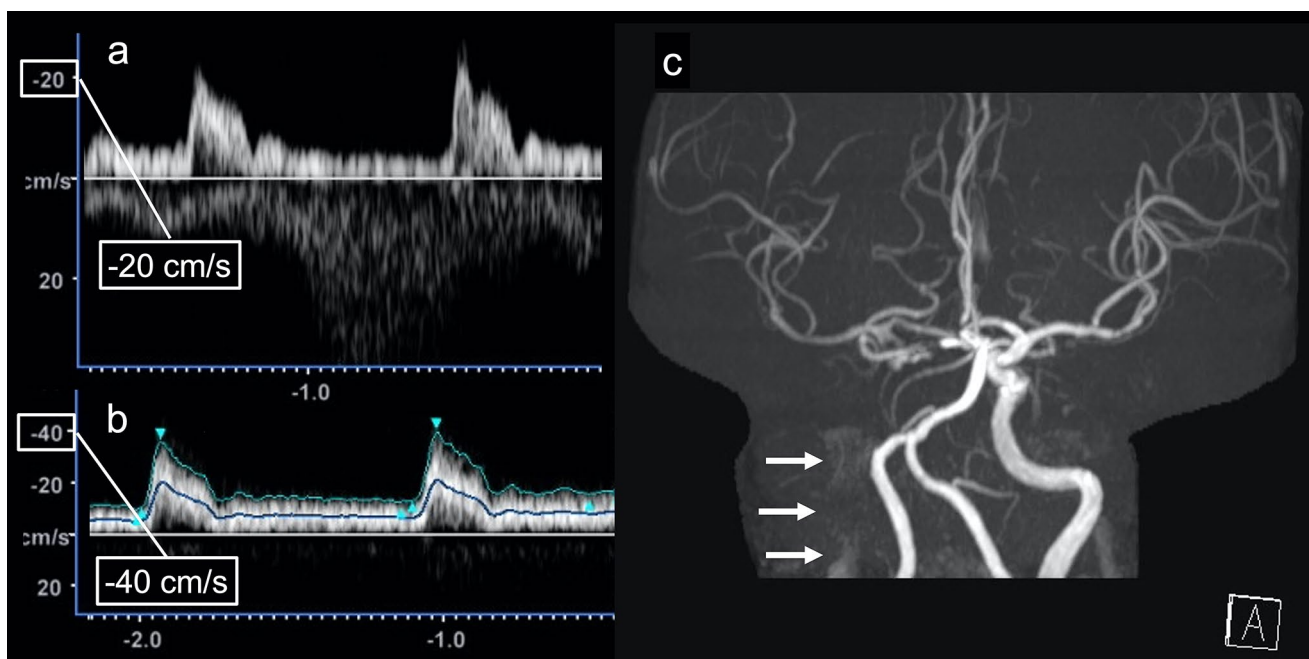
Ultrasound findings of ICA occlusion. Pulsed-wave Doppler ultrasound (a, b) and MRA (c) are shown. The EDV values of the right (a) and left (b) CCA are 4.8 cm/s and 12.9 cm/s, respectively. Therefore, the ED ratio is 2.7. MRA (c) reveals occlusion of the left
